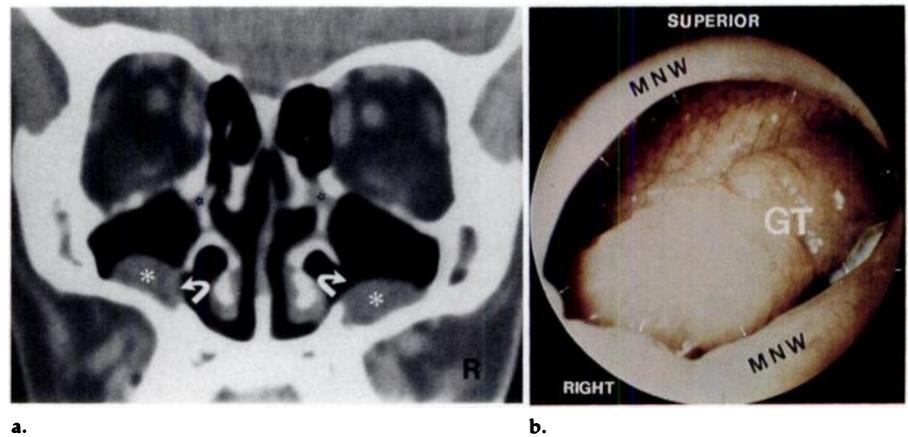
Maxillary inflammatory changes persisting despite bilateral nasal anastomies (nasoantral windows). (a) Coronal CT scan discloses that anastomies (arrows) are patent bilaterally; however, mucoperiosteal inflammation remains along the floor of the maxillary sinuses (*). This is not an incidental finding, since inflammatory mucosa occludes each infundibulum (*). *R* = right. (b) Endoscopist's view from the nasal cavity through the patent nasal anastomy (arrows) in the medial nasal wall (*MNW*) shows granulation tissue (*GT*) as the specific inflammatory reaction along the antral floor.
